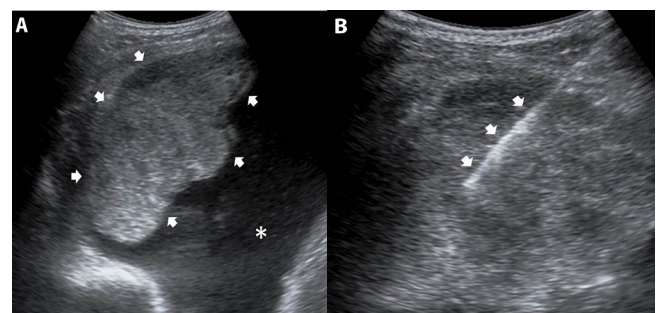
A: The solid lesion is clearly shown on the ultrasound study (indicated by arrowheads), outlined by the pleural effusion (indicated by *). B: Confirmation of the biopsy needle (indicated by arrowheads) within the centre of the solid mass is shown on ultrasound during the image-guided intervention.
